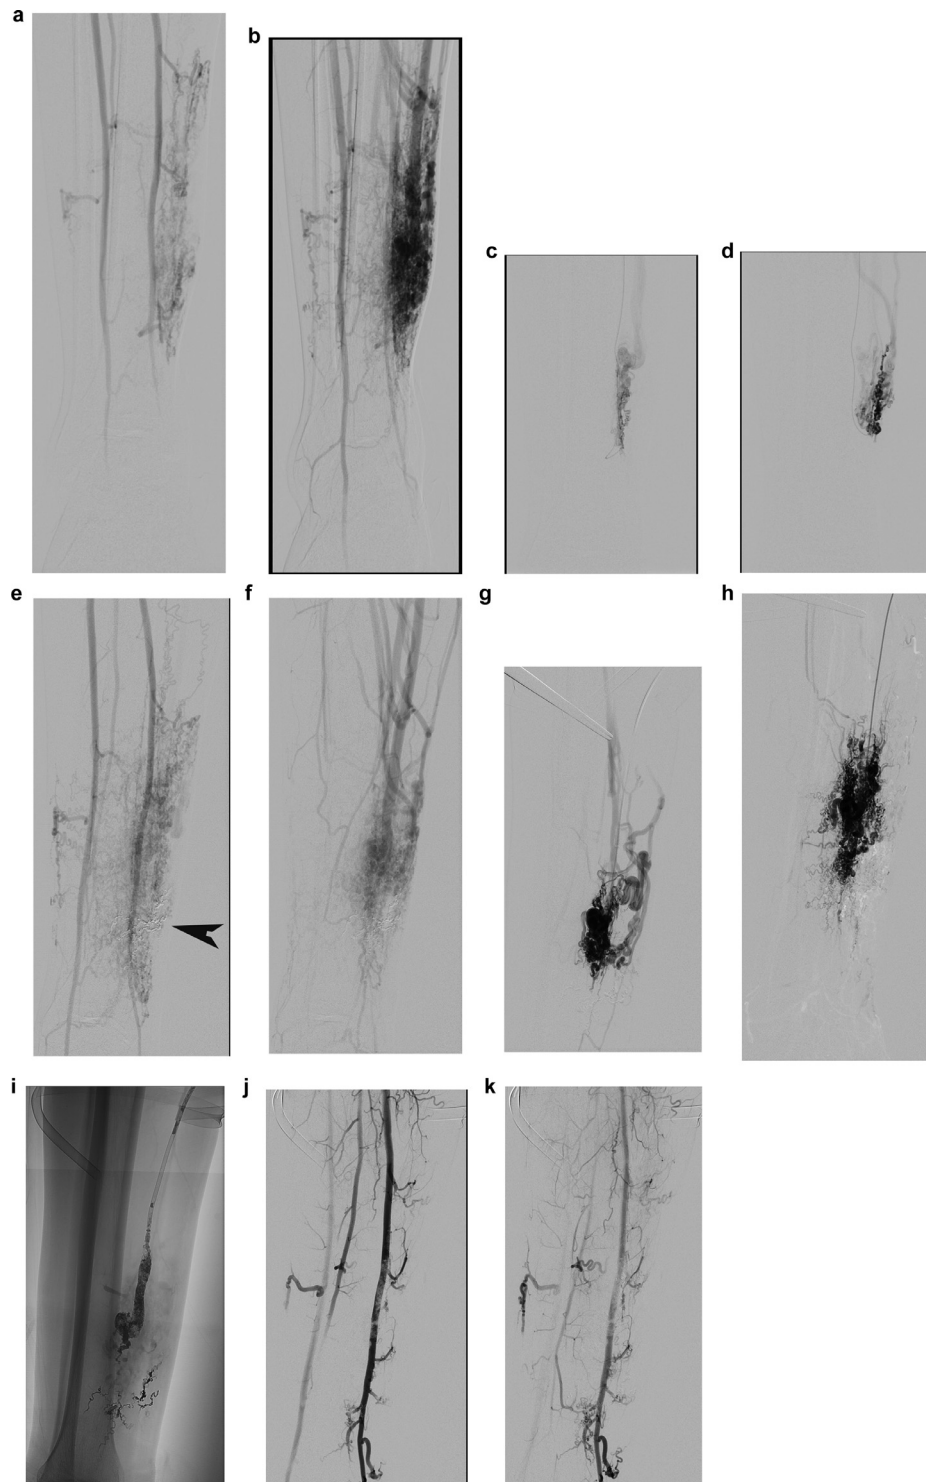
Patient with a leg AVM and chronic ulceration. (a,b) DSA showing a complex AVM with multiple arteriolar feeders arising from the posterior tibial and drainage in a dominant tibial vein and several collateral veins draining into the peroneal vein. This AVM was classified IIIB Cho and II Yakes. (c,d) Selective catheterization of arterial feeders followed by Onyx injection. (e,f) No clinical improvement and persistent AVM on control DSA with dominant drainage through the posterior tibial vein. The Onyx cast is shown (arrowhead) (e). (g,h) Retrograde puncture of the posterior tibial vein under ultrasound guidance and retrograde nidus embolization using proximal tourniquet to reflux in the nidus with ethanol. Following ethanol embolization, first the venous side of the nidus is occluded (g). Then, it is possible to reflux into the arterial side (h). (i) Occlusion of the posterior tibial vein was completed with glue. (j,k) Final DSA showing a complete cure of the AVM. The patient had a complete healing of the leg ulceration.
